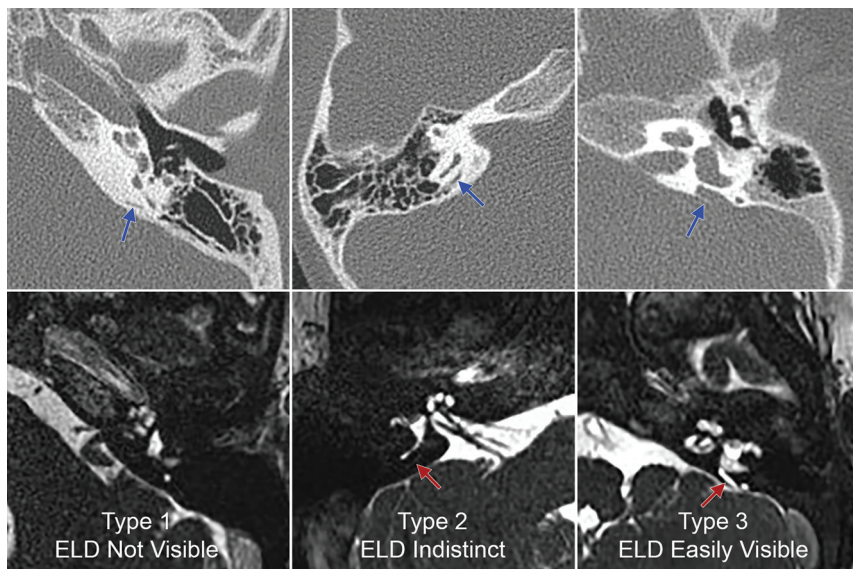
Examples of the 3 types of ELD visibility observed on MR imaging. *Upper row*, Representative axial-view non-contrast-enhanced temporal bone CT images of 3 different ears from different patients. *Lower row*, Axial temporal bone CISS MR images corresponding to the same ears as the CT images directly above demonstrate type 1 (lower left image), type 2 (lower middle image), and type 3 ELDs (lower right image). *Blue arrows* in the upper row indicate the vestibular aqueducts; *red arrows* in the lower row indicate the visible ELDs.
